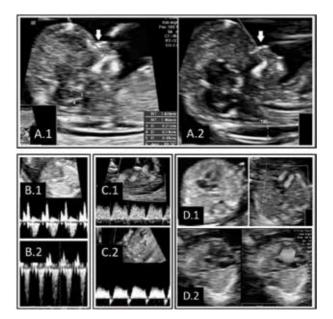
First-trimester ultrasound genetic markers. (A) Measurement of the cranial markers: nuchal translucency (NT), nasal bone (NB, white arrow), and fronto-maxillary facial angle (FMF, figured with red lines). (A.1) Normal values of genetic markers with small NT thickness, ossified nasal bone, and normal facial angle. (A.2) Abnormal genetic markers with increased NT thickness, absent nasal bone, and wide facial angle, of more than 90°. (B) Spectral Doppler assessment of the tricuspid flow and measurement of the fetal heart rate. (B.1) Normal tricuspid blood flow. (B.2) Regurgitation of the blood flow across the tricuspid valve. (C) Spectral Doppler assessment of the ductus venosus flow. (C.1) Normal ductal blood flow. (C.2) Abnormal ductal flow with reversed a-wave. (D) Assessment of the four-chamber view of the fetal heart in duplex mode: gray scale and color Doppler. (D.1) Normal appearance of the four-chamber view with identification of the crux cordis in gray scale and equal and separated atrioventricular flows. (D.2) Atrioventricular septal defect with common atrioventricular valve and large communication between heart cavities.
